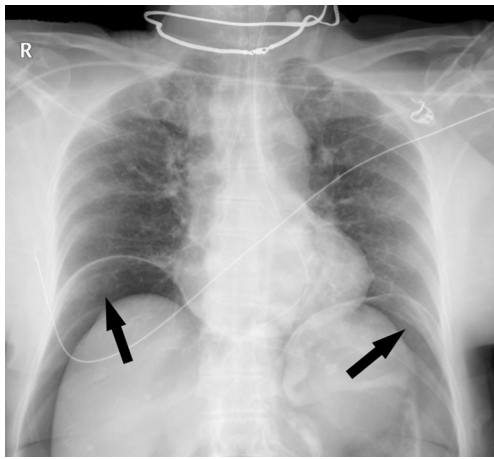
Chest radiography showing massive air content beneath both diaphragms. (arrows)
